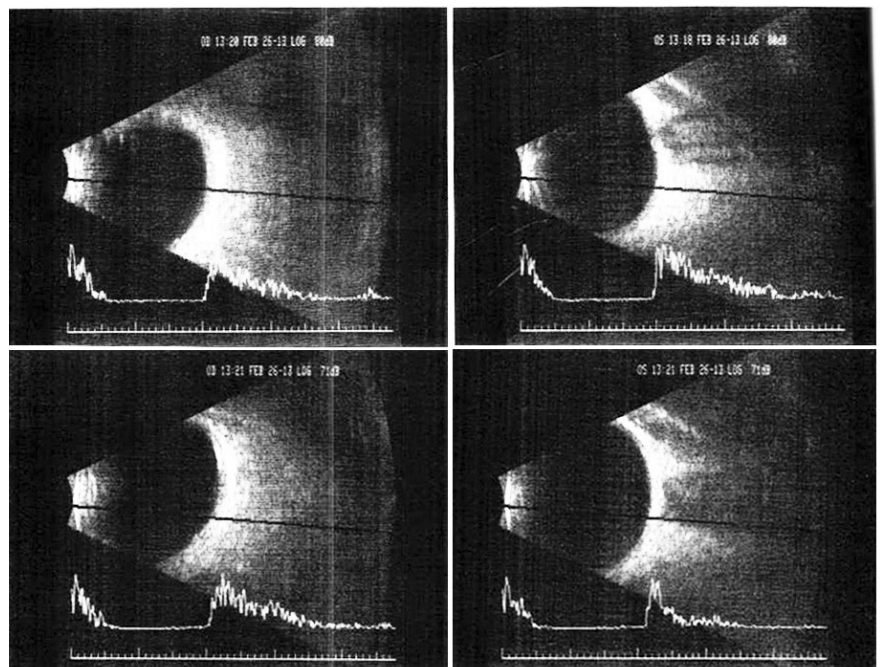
B-scan ultrasound of the left eye. No elevation, gross masses, or abnormalities identified. Some flattening of the posterior pole in the top right scan.
